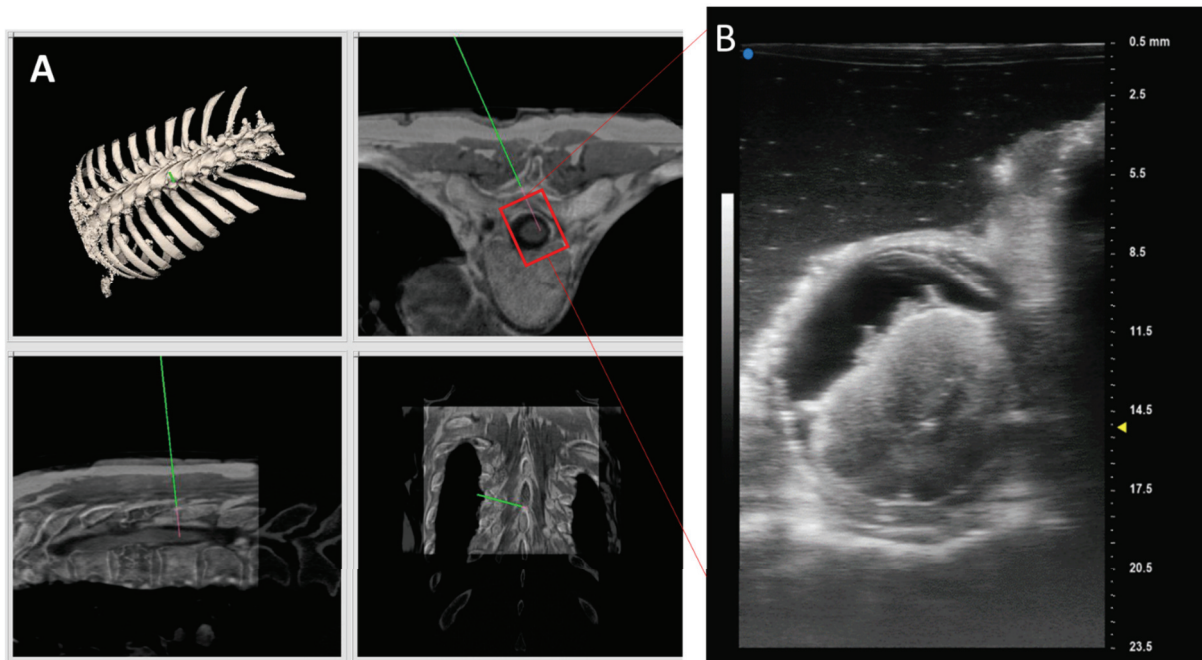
Patient 1: Tracked axial intraoperative high frequency  $\mu$ US images acquired at 30 MHz. A) Tracking information – field of view (Red Box) and trajectory (Green Line) of the ultrasound probe as tracked by the navigation system. B) Representative  $\mu$ US axial image.
